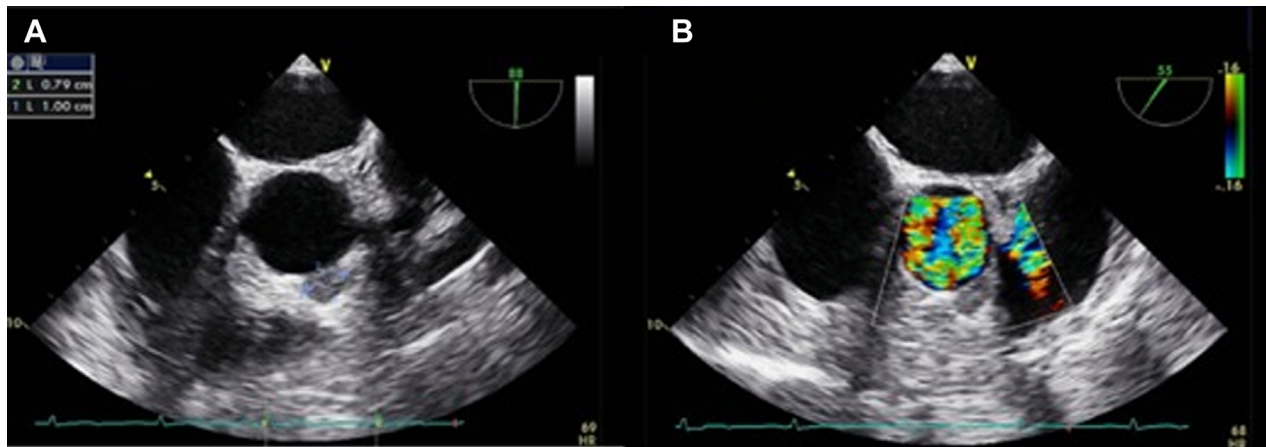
Preoperative Transesophageal Echocardiography
